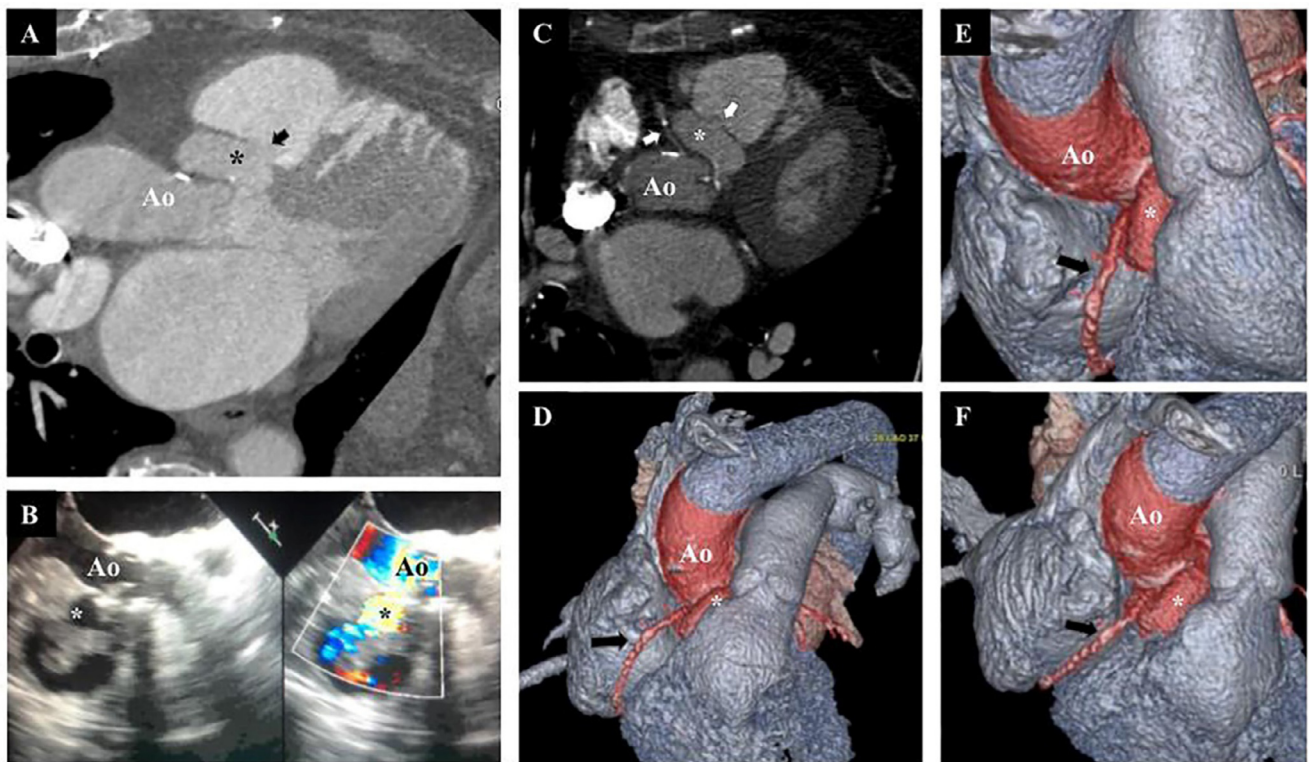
Ao: Aorta. Image A: cardiac axial plan, showing the pseudoaneurysm of the aortic root (black star) and the fistula communication with RVOT (black arrow). Image B: Echocardiographic imaging of the fistula (white star) and evidence of the flux through the communication at Doppler evaluation (black star). Image C: Cardiac multiplanar reconstruction highlighting the compression of the right coronary artery (white star) by the pseudoaneurysm (white star). Fistula between RVOT and aneurysm (white arrow). Image D, E, F: 3 different views of Volume Rendering reconstruction showing the compressed right coronary artery (black arrow), the pseudoaneurysm (white star), and proximal aortic tract (Ao).
